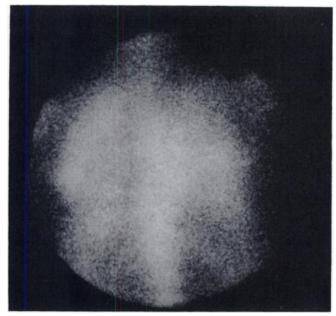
Gallium-67 scintigram from the case presented. It is a posterior view of the chest and upper abdomen in which the chest tracer uptake is greater than the liver and abdomen. The index is 308.
